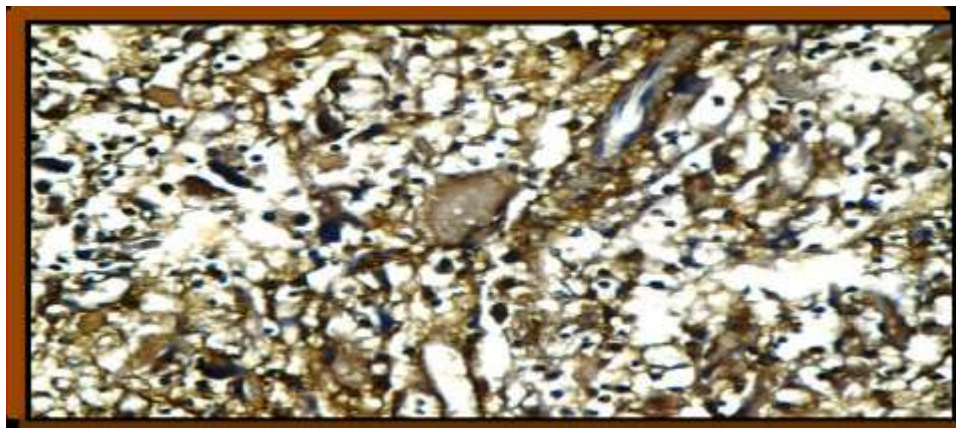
PXA showing positive endothelial cytoplasmic and membranous expression of PSMA. Original magnification power 200x.
